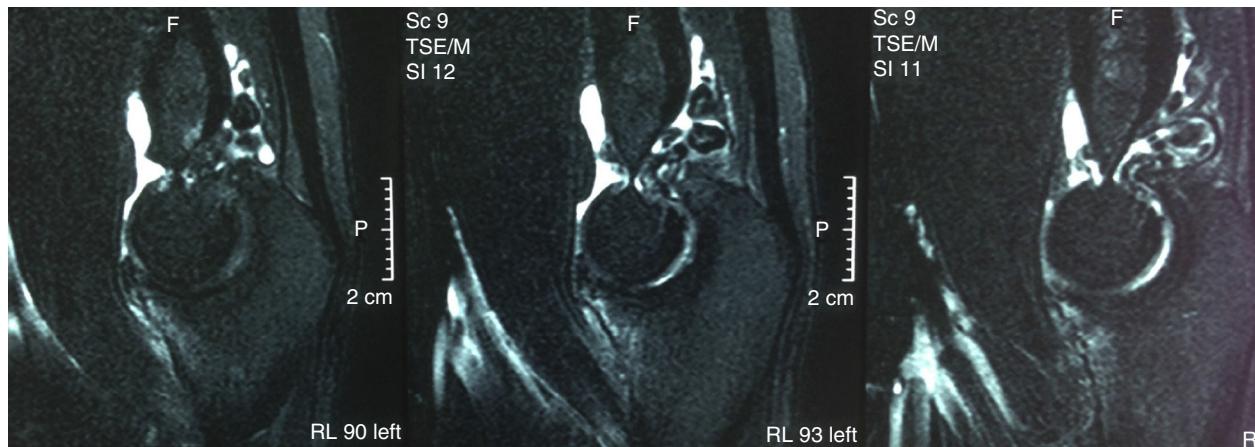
T2-weighted sagittal magnetic resonance imaging showing many free bodies in the fossa of the olecranon.
